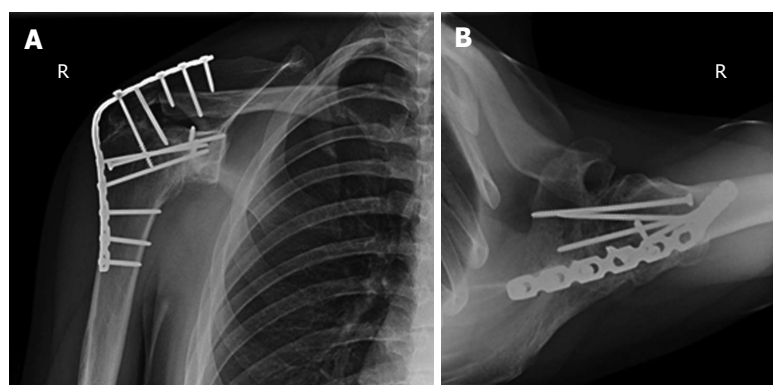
Antero-posterior (A) and axillary view (B) radiographs six months following shoulder fusion after failure of a combined HemiCap and Latarjet procedure in an epileptic patient with massive bipolar bone loss.
